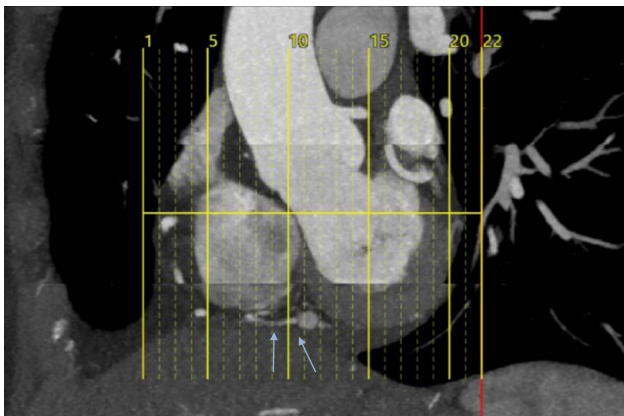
Computed tomography angiography of the coronary arteries revealing non-obstructive dissection flap
